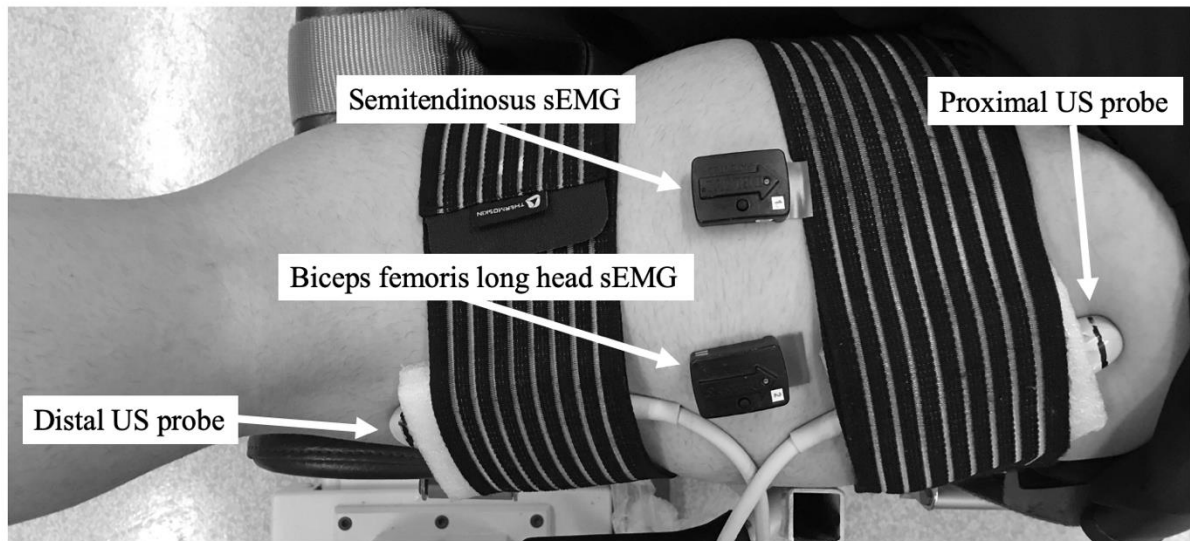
The participant was positioned lying prone on the dynamometer. The positions of the proximal and distal ultrasound probes and the sEMG sensors position on biceps femoris long-head and Semitendinosus are pictured.*
